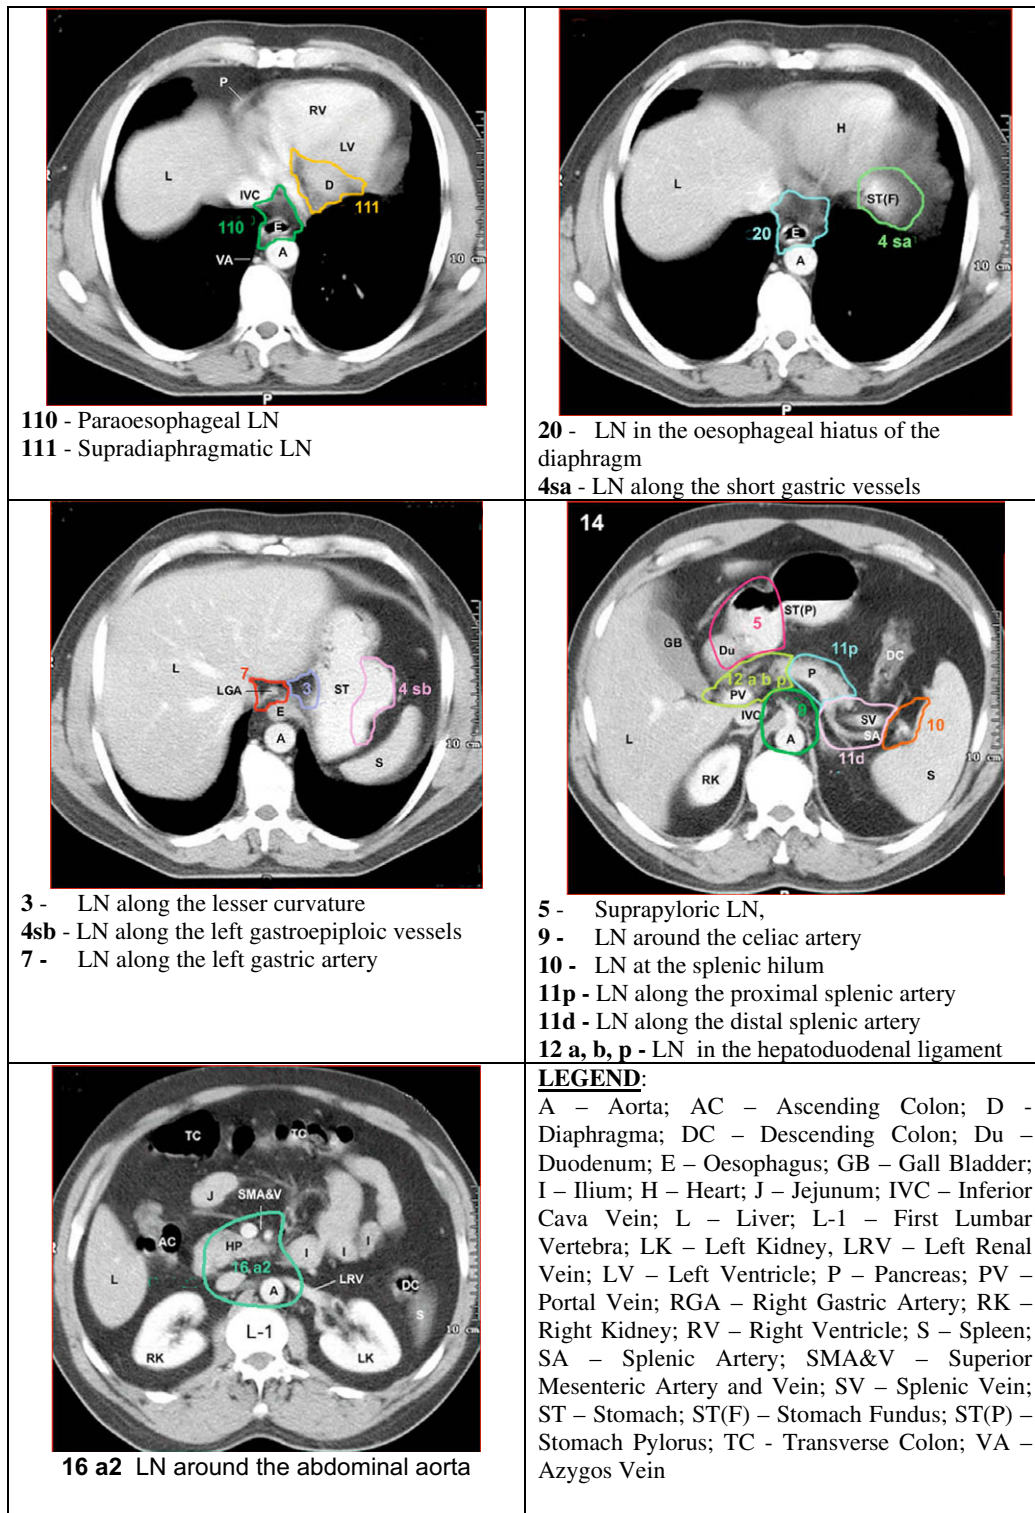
Examples of lymph node stations on the corresponding CT slices.
